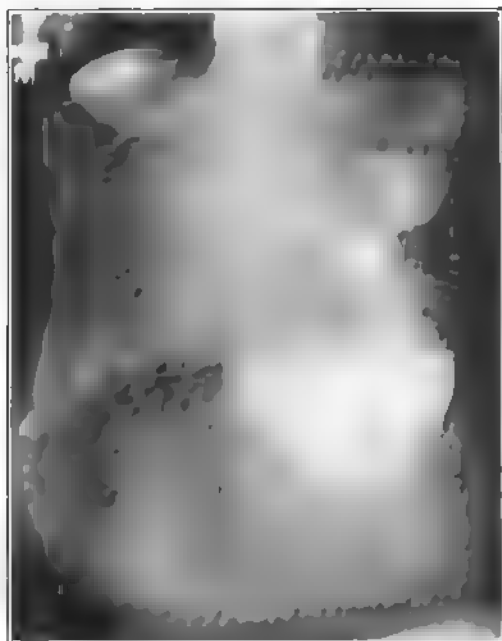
(Case No. A77,596, X-ray No. 18,595.) Female, aged 54. Hour-glass stomach, fish-hook type, displaced to the left, extending below umbilicus, showing diverticulum just outside stomach outline on lesser curvature. Diverticulum contained bismuth after the upper loculus had emptied. Diagnosis: Diverticulum due to perforating ulcer of the stomach. Operation: Perforating ulcer of stomach, perforating into the liver.
